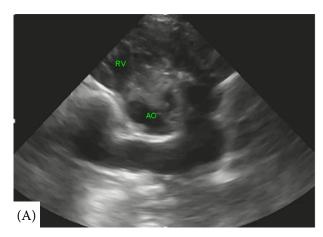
The contrast echocardiogram using agitated saline. The right parasternal short axis view. The microbubbles moved from the right ventricle to the aorta through the ventricular septal defect (A) and then appeared in the main pulmonary artery (arrows) via the patent ductus arteriosus (B). The right ventricular outflow tract was not filled with bubbles (B). Instead, the bubbles flowed from the ductus (d) to the main pulmonary artery and were then regurgitated into the small distal section of the right ventricular outflow tract at diastole
